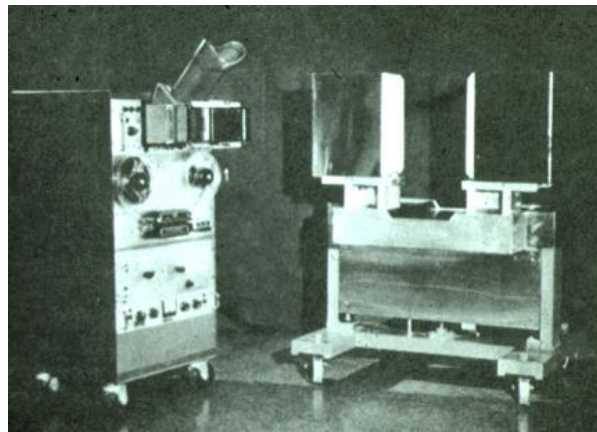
PC-I The First Tomographic Imaging Device and the First Computed Tomographic Imaging Device (PET): 1968-1971
